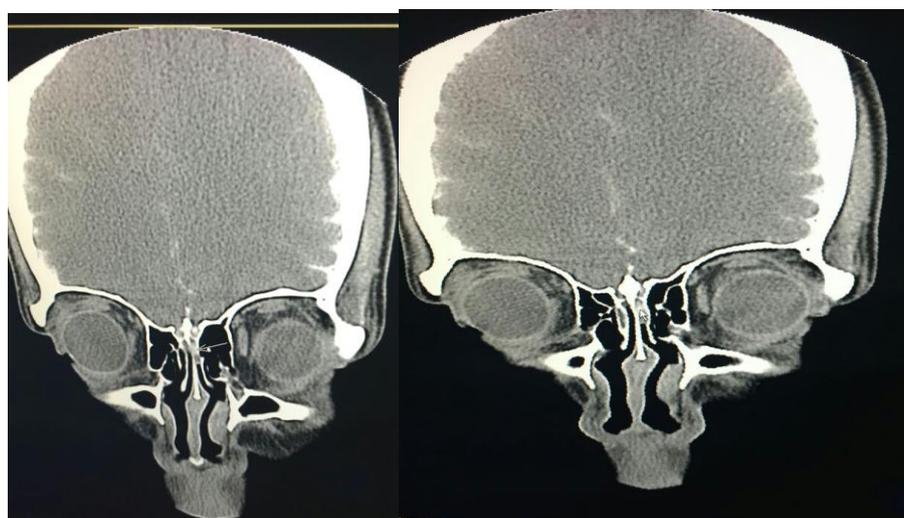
CT cisternography showing leak at roof of ethmoid
